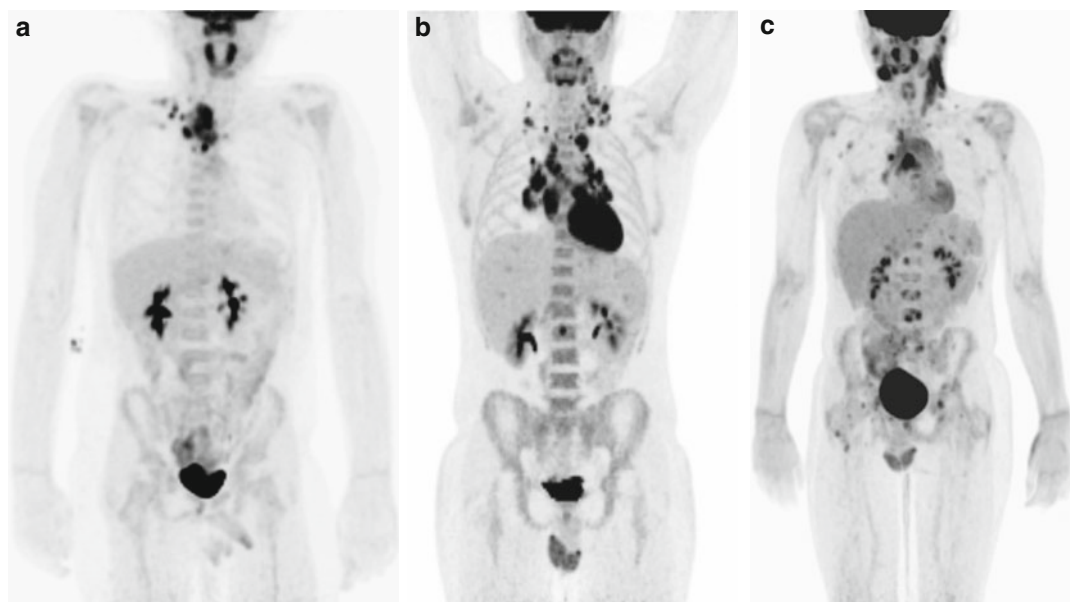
Using ^{18}F -FDG PET and PET/CT to stage Hodgkin's disease. Fluorine-18-FDG PET has a role when using the modified Ann Arbor criteria for staging pediatric Hodgkin's disease. (a) Stage II: In a 16-year-old male with stage II nodular sclerosis classic Hodgkin's disease, there is FDG-avid disease in the mediastinum and right supraclavicular lymph nodes. No FDG-avid disease is identified below the diaphragm. (b) Stage III: In a 15-year-old male with stage III nodular sclerosis classic Hodgkin's disease, there is FDG-avid disease in the mediastinum and lymph nodes of both supraclavicular regions, as well as in a single
